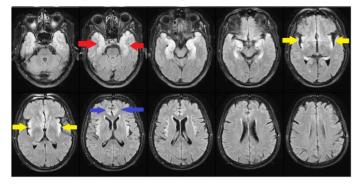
Herpes encephalitis-Axial T2 and FLAIR images showing symmetrical areas of hyperintense signal in bilateral medial temporal lobe, hippocampi (red arrow), insular cortex (yellow arrow) and cingulate gyrus (blue arrow).
